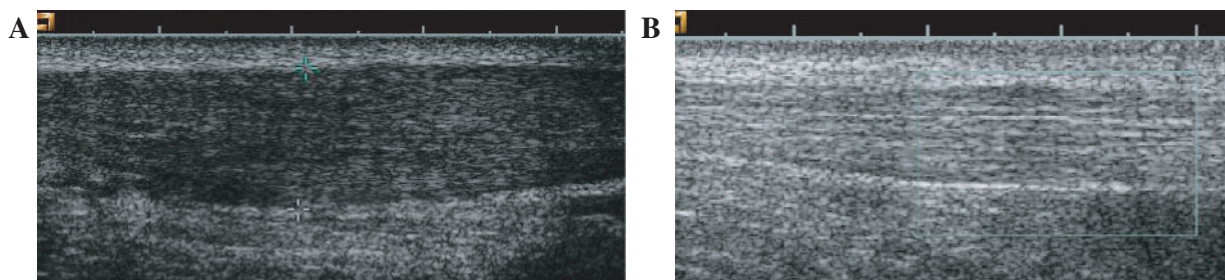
Ultrasound appearance of Achilles tendon before and after a long-term eccentric loading programme. (A) Typical appearance of a hypoechoic Achilles tendon prior to commencing an eccentric loading programme. (B) The appearance after a long-term eccentric loading programme. Loss of hypoechoic appearance and reduced tendon thickening are demonstrated. (Reproduced from Öhberg L, Lorentzon R, Alfredson H. Eccentric training in patients with chronic Achilles tendinosis: normalised tendon structure and decreased thickness at follow up. *Br J Sports Med* 2004;38:8–11 with permission from the BMJ Publishing Group.)
